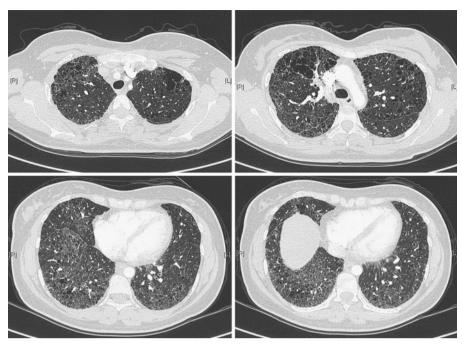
High-resolution computed tomography of the chest of adult non-smoking patient demonstrating centrilobular emphysema in the upper zones of the lungs, and diffuse, infiltrative lung disease in the lower zones, including bilateral reticulation without subpleural predominance, traction bronchiectasis, architectural distortion and ground glass attenuation.
